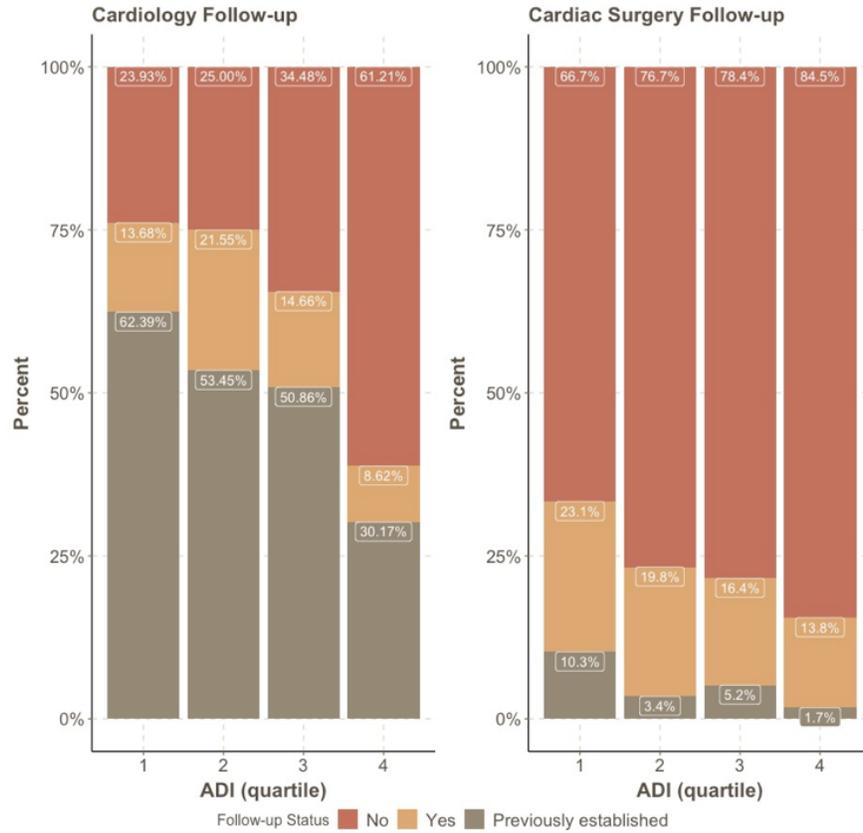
Cardiology and cardiac surgery follow-up status after index scan. Follow-up status is defined as having completed a consultation appointment with either a cardiologist or cardiac surgeon, specifically for aneurysm monitoring, at any date after the index computed tomography scan identifying ascending thoracic aortic aneurysm. Those with records of having attended an appointment with either specialty in the past for aneurysm monitoring were included in a separate category (‘Previously established’). Increasing ADI quartile corresponds with increasing socioeconomic deprivation. Percentages represent proportion of patients within each category by quartile.
